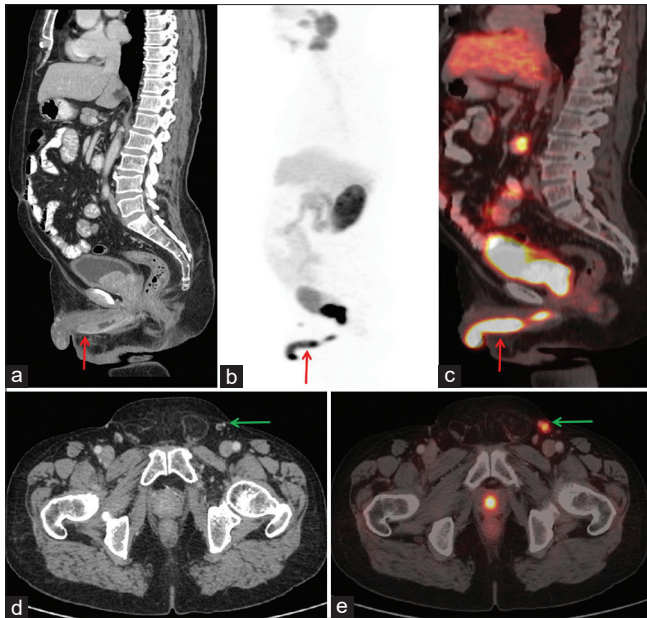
(a) Computed tomography, (b) Ga-68 prostate-specific membrane antigen positron emission tomography maximum intensity projection image, and (c) Ga-68 prostate-specific membrane antigen positron emission tomography/computed tomography image showing the metastatic lesion (red arrows). The axial image of (d) computed tomography and (e) Ga-68 prostate-specific membrane antigen positron emission tomography/computed tomography showing the uptake in the left inguinal nodes (green arrow)
